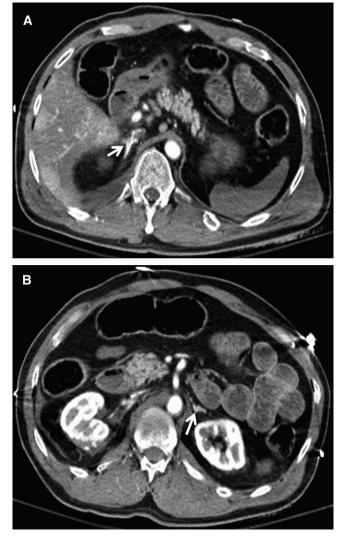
Contrast-enhanced computed tomography of the abdomen, demonstrating hyperenhancement of the right (A) and left (B) adrenal glands (arrow in A and in B) as well as splenic hypoperfusion.
